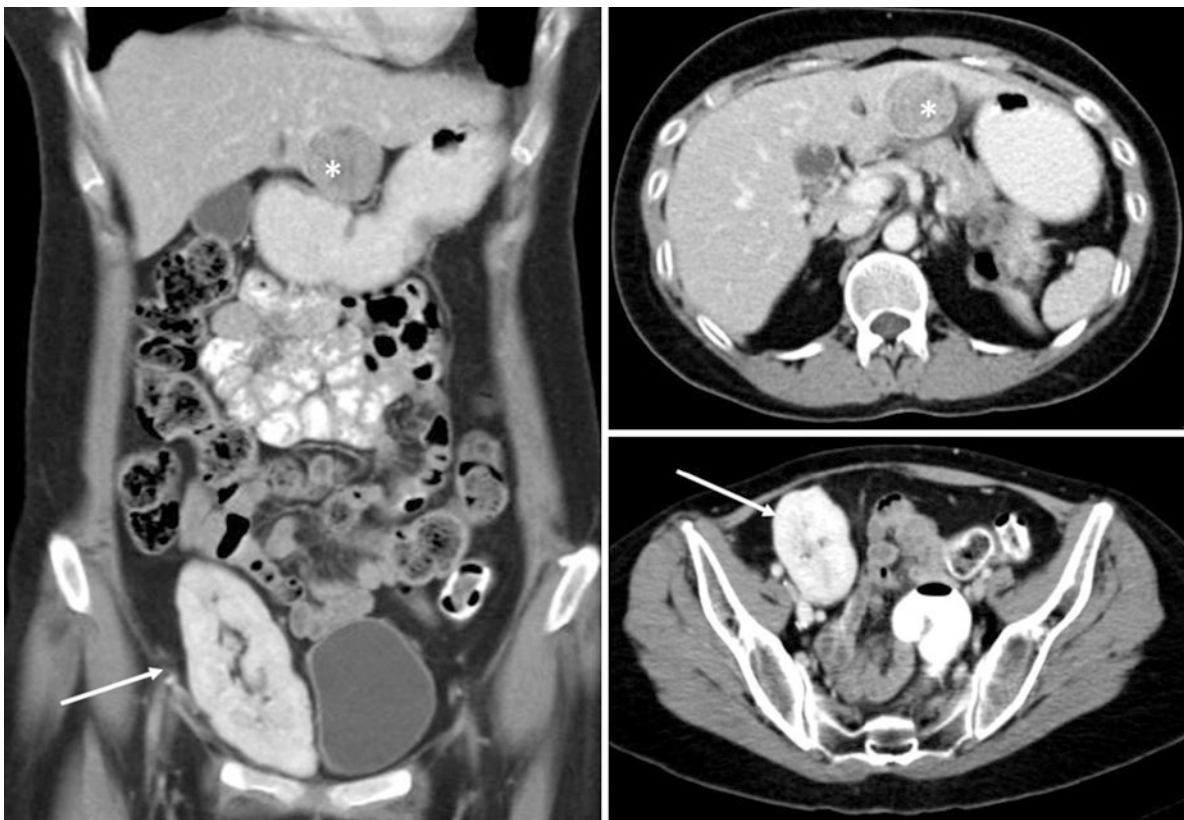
Contrast-enhanced CT abdomen shows evidence of soft tissue mass in the liver (*). Note the transplant kidney in the right iliac fossa (white arrow)
